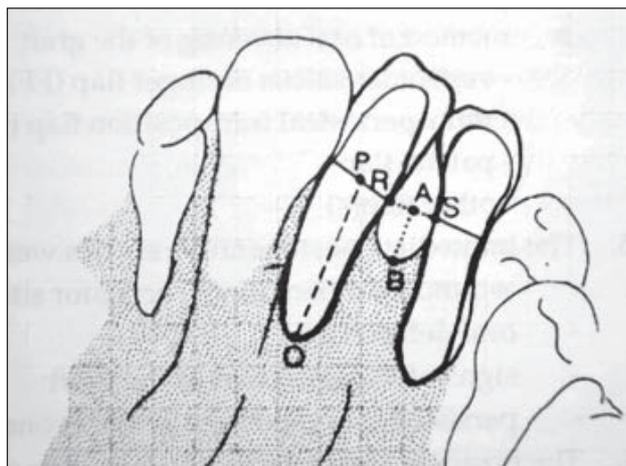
The scheme of bone bridge height measurement in occlusal radiographs of the cleft area according Coole [6].
